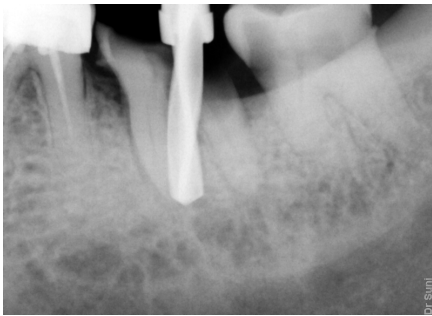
Pre-Operative IOPA X-ray
